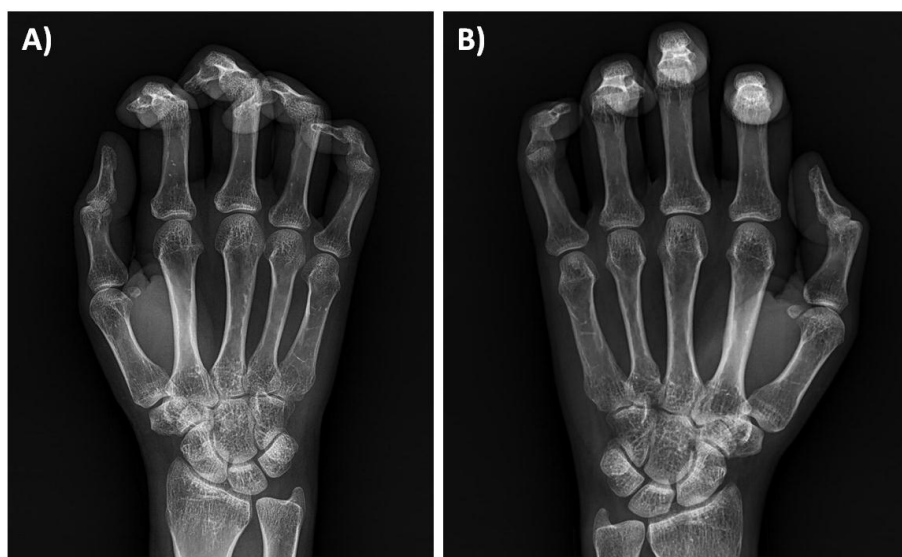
X-ray image of patients both hands: A) Left hand; B) Rt. Hand.
